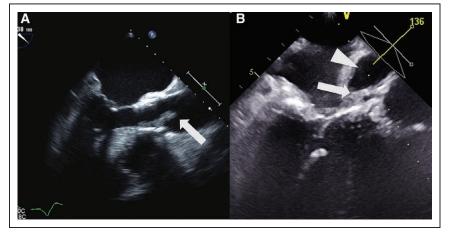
Transesophageal echocardiogram images of transcatheter aortic valve vegetations.
